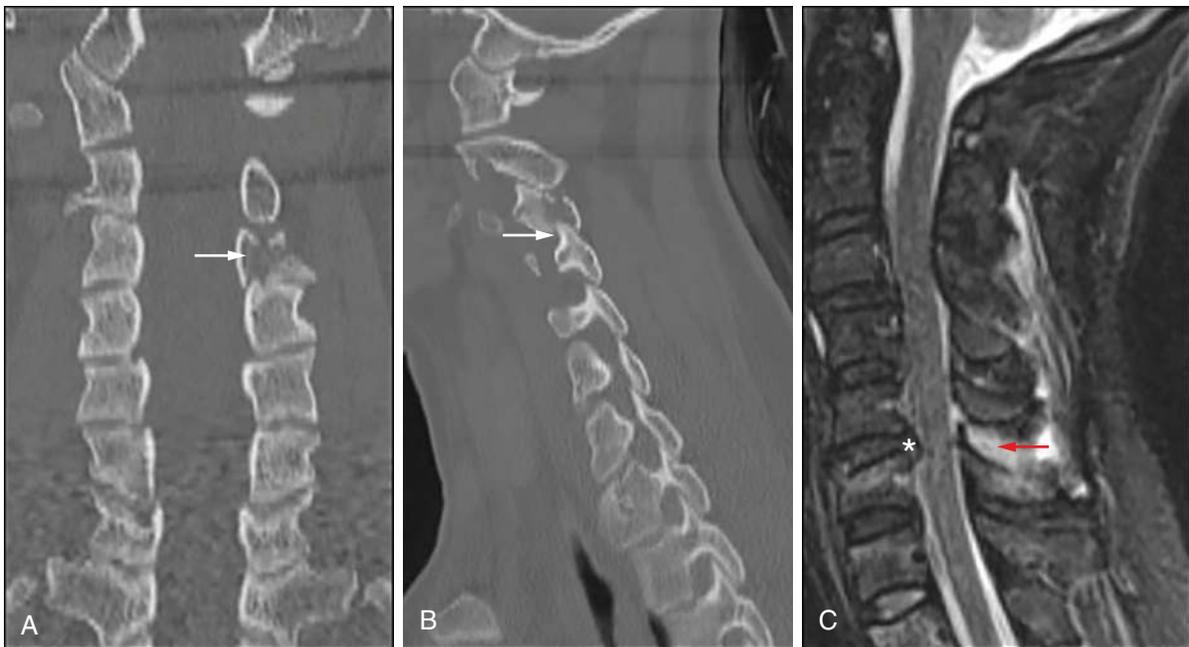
Cervical spine trauma. A and B, CT of the cervical spine viewed in coronal and sagittal reconstructions shows an acute comminuted fracture of the C3 left articular pillar with subluxation, or perching, of this pillar on the C4 articular pillar (*white arrows*). C, Short-tau inversion recovery (STIR) MR image in the same patient shows a traumatic C5–C6 intervertebral disc herniation (*white asterisk*) and injury to the C5–C6 interspinous ligament, as evidenced by hyperintense signal (*red arrow*). These soft tissue injuries were not suspected based on the findings of CT and demonstrate the utility of MRI for detecting additional soft tissue injuries.
